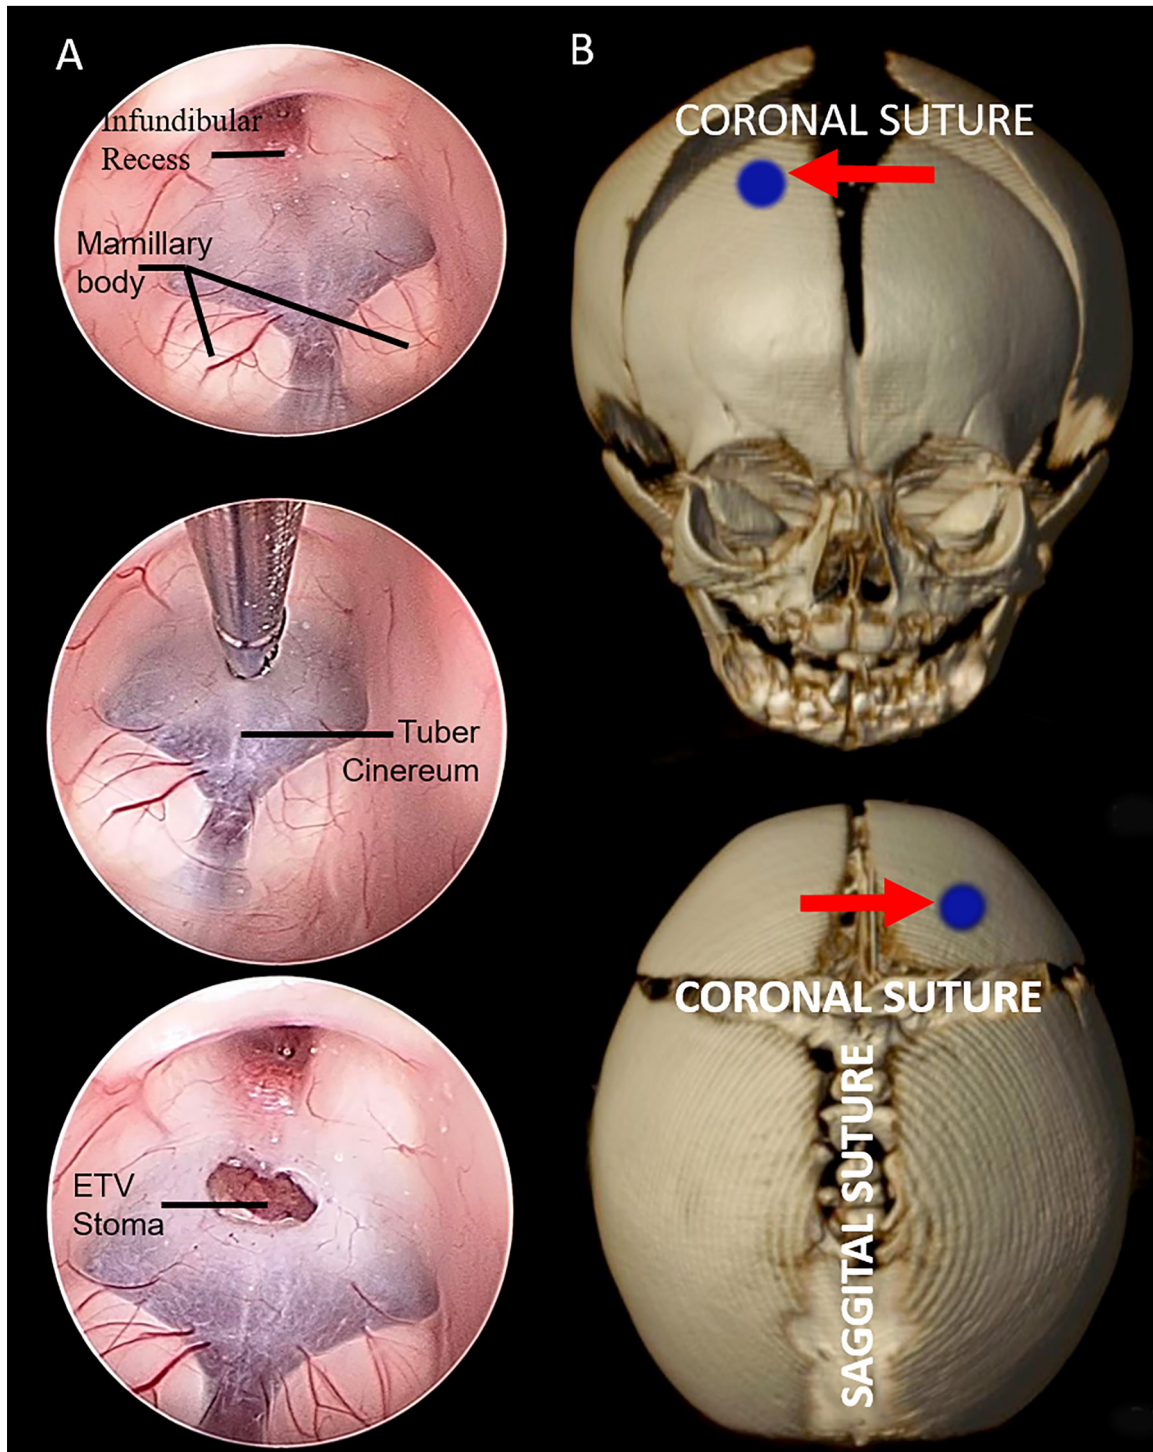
A. Three-Dimensional Computed Tomography (3D CT) scan of the appropriate entry point to be selected in endoscopic surgery, B. The appearance of the surgical area and stoma endoscopically in intraoperative ETV surgery
